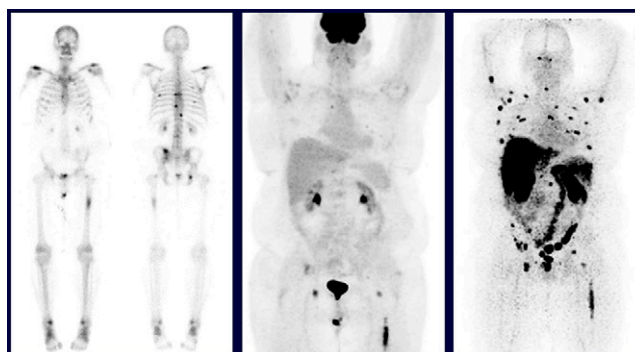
^{89}Zr -IAb2M minibody imaging. Images acquired in a man with metastatic prostate cancer and rising prostate-specific antigen with: (left) $^{99\text{m}}\text{Tc}$ bone scanning; (middle) ^{18}F -FDG PET; (right) ^{89}Zr -Df-IAB2M anti-PSMA minibody imaging.
